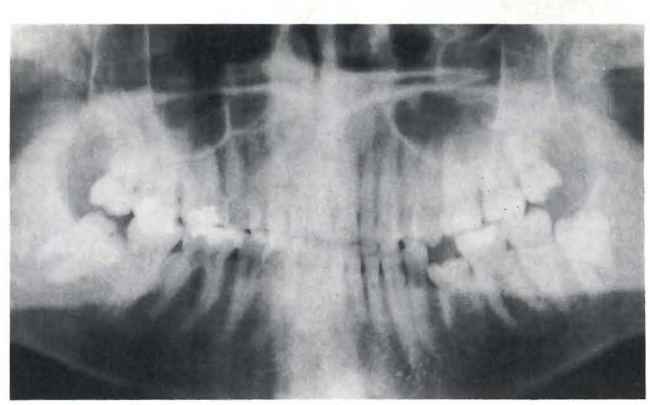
Orthopantomogram of a twenty-five-year-old man with secondary retention of the left second primary mandibular molar without a successor. No treatment was performed.
